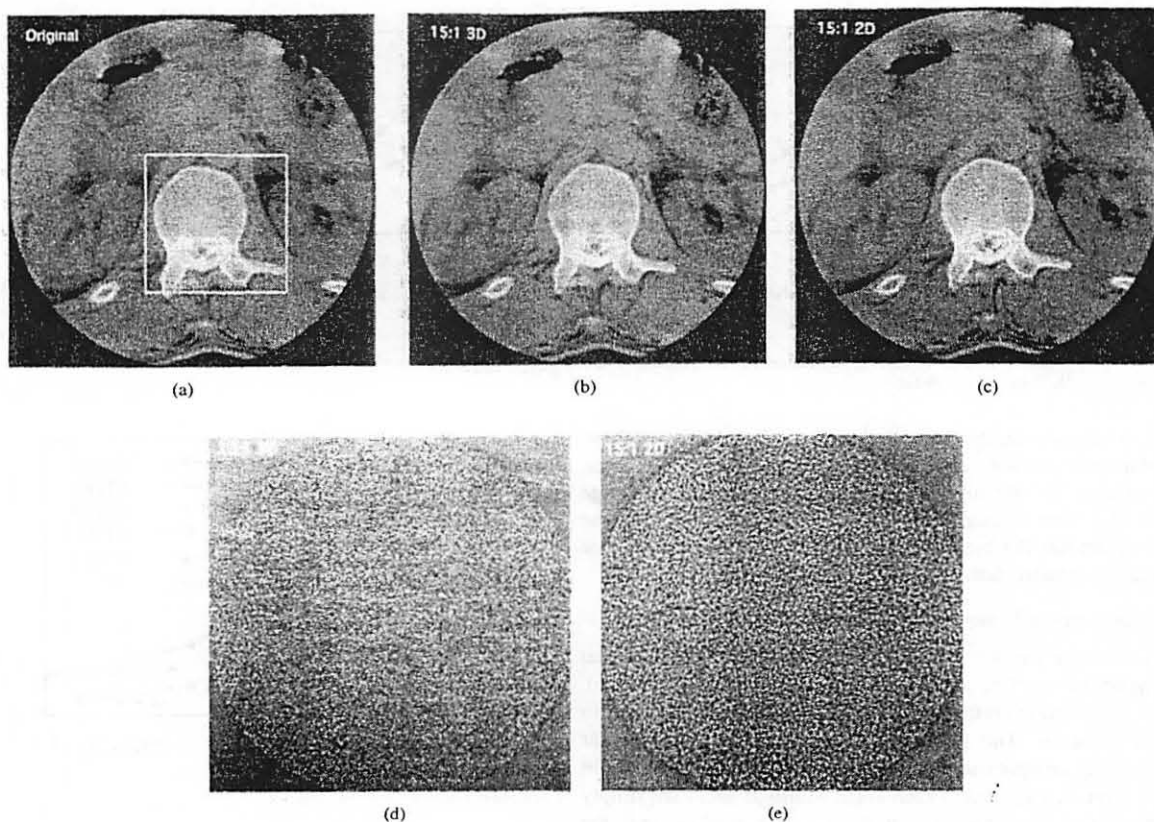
One slice of a CT volume image data compressed at compression ratio of 15:1 using 3-D wavelet and 2-D wavelet algorithms. (a) original image, (b) image compressed with the 3-D wavelet method, (c) image compressed with the 2-D wavelet method, (d) the difference image between (b) and (a), and (e) the difference image between (c) and (a).
